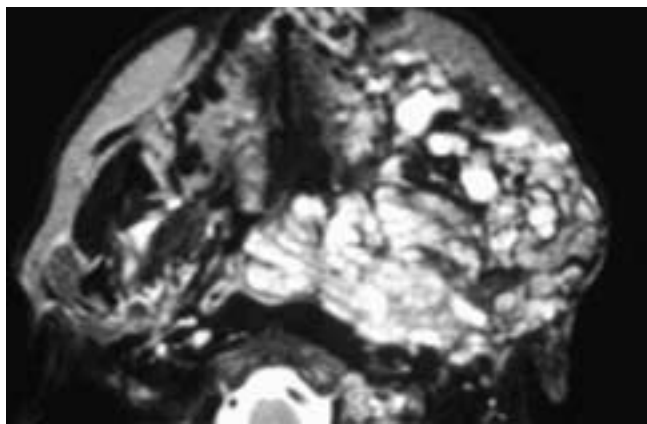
Axial T2-weighted MR scan shows multiple cystic components of varying size forming part of an overall bulky and infiltrating mass. The lesion involves the parotid gland, the adjacent superficial soft tissues in the face, and the deeper planes in the pharynx. This patient had a cystic lymphangioma.
